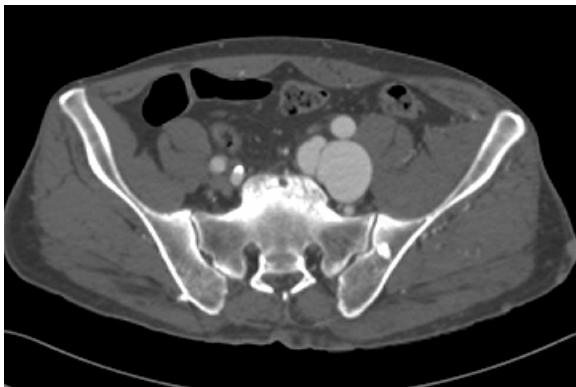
Contrast enhanced CT scan shows left internal iliac arteriovenous fistula (AVF) (short arrow) and marked dilatation of Lt internal (long arrow) and external iliac vein. Dilated collateral vein is also noted in Lt subcutaneous layer.
